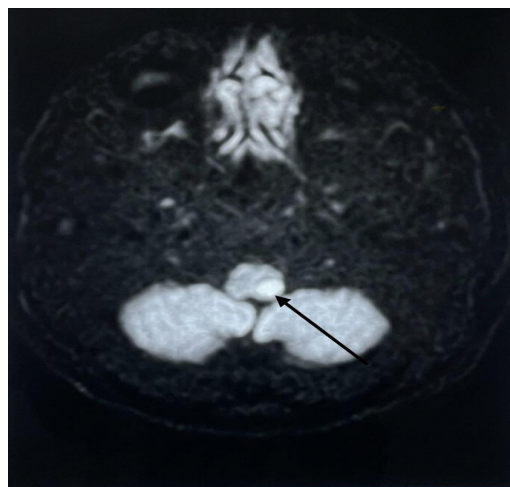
MRI Brainstem Diffusion-Weighted Image showing an Acute Infarct in the left Lateral Medulla Consistent with Lateral Medullary Syndrome
